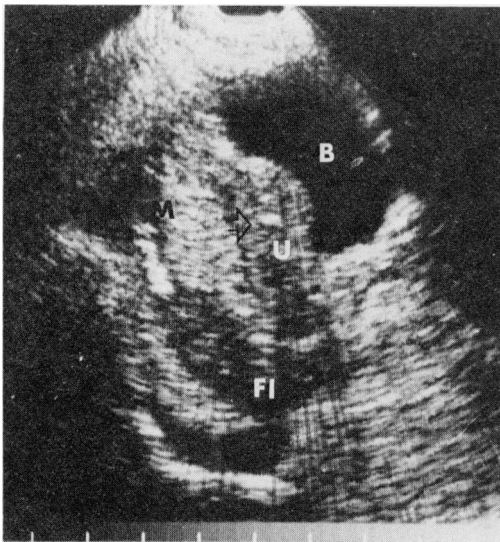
The longitudinal ultrasound of the pelvis shows the bladder (B) indented by the uterus (U) containing the IUD (*open arrow*). There is fluid in the cul-de-sac (Fl.). The mass (M) is seen posterior to the uterus.
